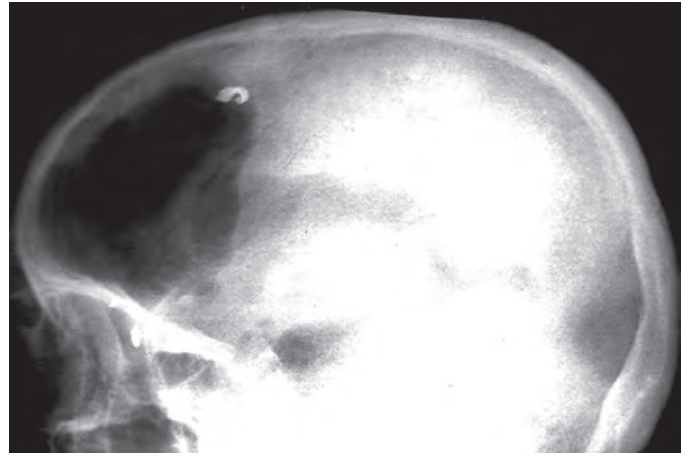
Skull X-ray showing intracranial splinter with pneumocephalus and air ventriculogram
